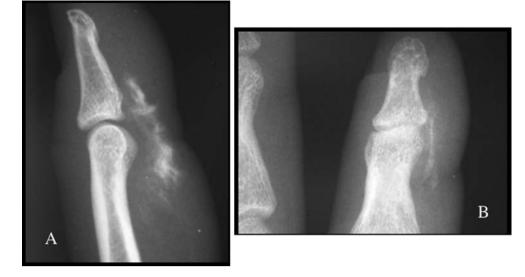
a and b Radiographs demonstrating the radio-opaque paint in a patient who sustained a paint-gun injury with latex paint. Although it appears that there is no obvious paint extension proximal to the middle phalanx, intraoperatively, paint was observed at the level of the distal portion of the A2 pulley.
